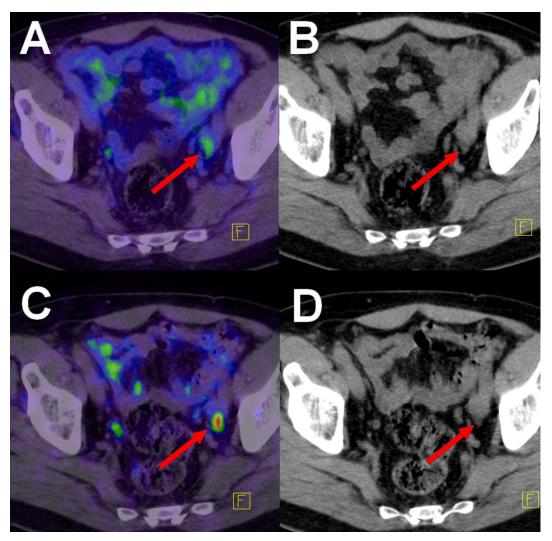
The majority of PCa lesions present with higher uptake and contrast at 3h p.i. compared to 1h p.i. Red arrows point to a LN metastasis adjacent to the intestines which was clearly visible at 3h p.i. (C-D) (SUVmax 5.7). At 1h p.i. (A-B) the slight uptake (SUVmax 2.2) was thought to be related to the background signal of the intestines as also visible in the upper parts of the sub-image A. A: fusion of PET and CT at 1h p.i., B: low dose CT at 1h p.i., C: fusion of PET and CT at 3h p.i., D: low dose CT at 3h p.i.
